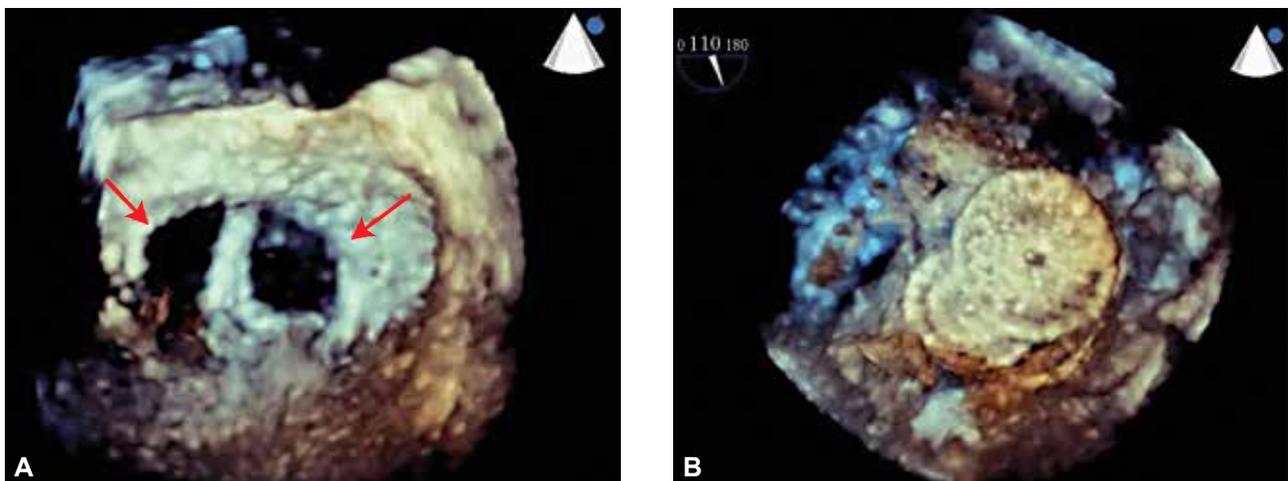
Real-time three-dimensional transesophageal echocardiography used in transcatheter closure of multiple atrial septal defects. (A) Before device deployment, two defects (red arrows) with a sufficient rim between the surrounding structures. (B) After deployment, the two devices can be seen overlapping each other to close the defects.
